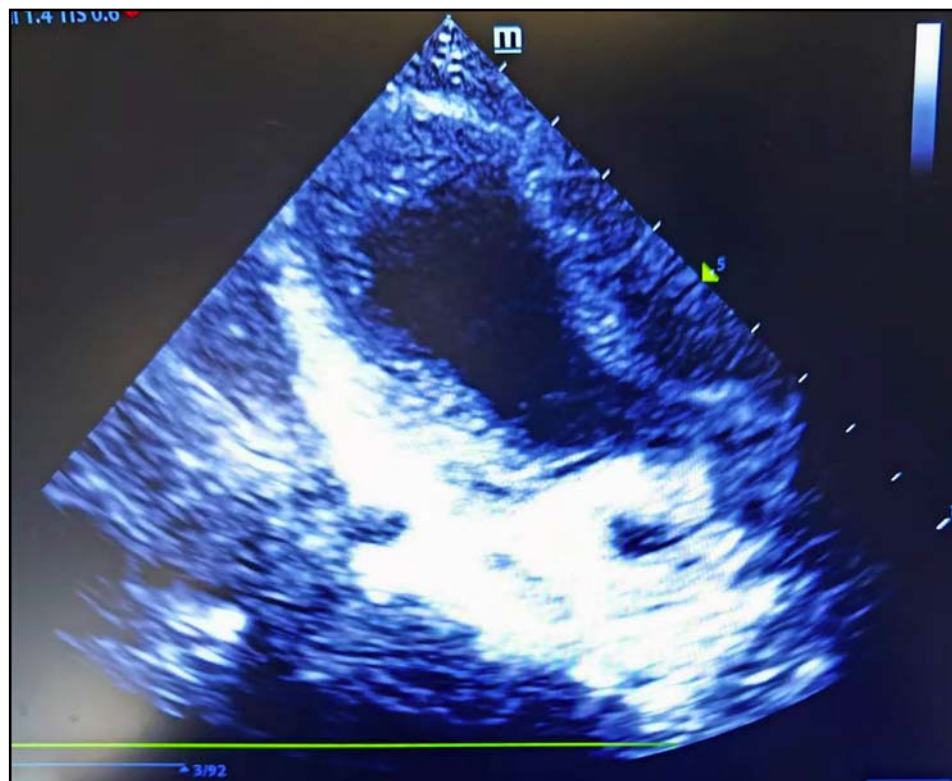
Echocardiogram findings revealed that the myocardium in the anterior wall of the left ventricle exhibited approximately normal thickness and echogenicity, coupled with a reduction in motion amplitude. Additionally, the midsection of the left ventricle underwent spherical expansion.
